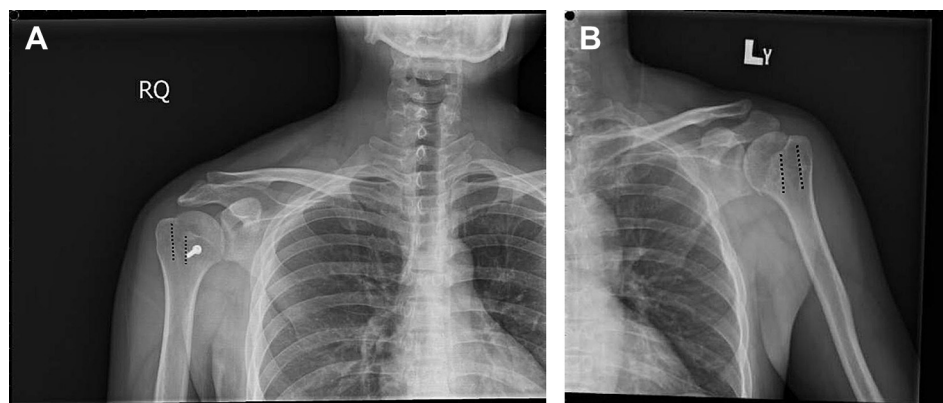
(A) Radiograph (anteroposterior view) of the right shoulder of Case 1 after the operation to reduce the shoulder dislocation. (B) Radiograph (anteroposterior view) of the left shoulder of Case 2 at final follow-up. The projection of the greater and lesser tuberosity borders form two vertical lines and an “M” cannot be seen.
